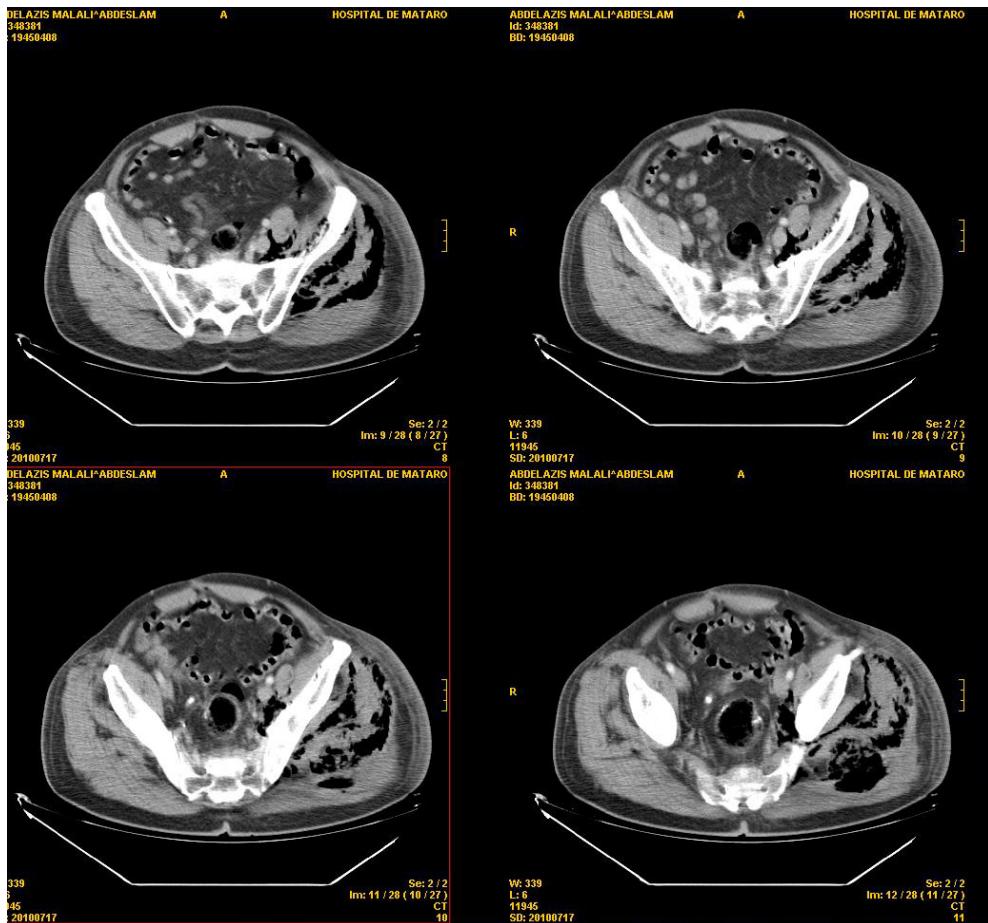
CT-Scan showing gas in gluteus and in the retroperitoneal space in a 66 years old patient with ascendant Fournier's Gangrene (Author's image)
